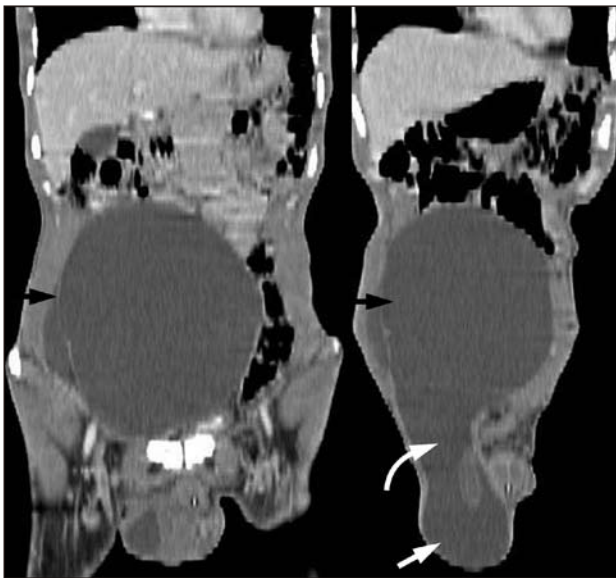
Contrast-enhanced coronal reformatted computed tomography images of the abdomen and pelvis demonstrating the extent of the abdominoscrotal hydrocoele (black arrows, abdominal component; curved white arrow, inguinal canal; white arrow, scrotal component). The cystic mass is well capsulated and extends from the abdomen through the inguinal canal to the scrotum. No ascites is present in the abdomen and pelvis. No solid component suggestive of neoplasm is present.
